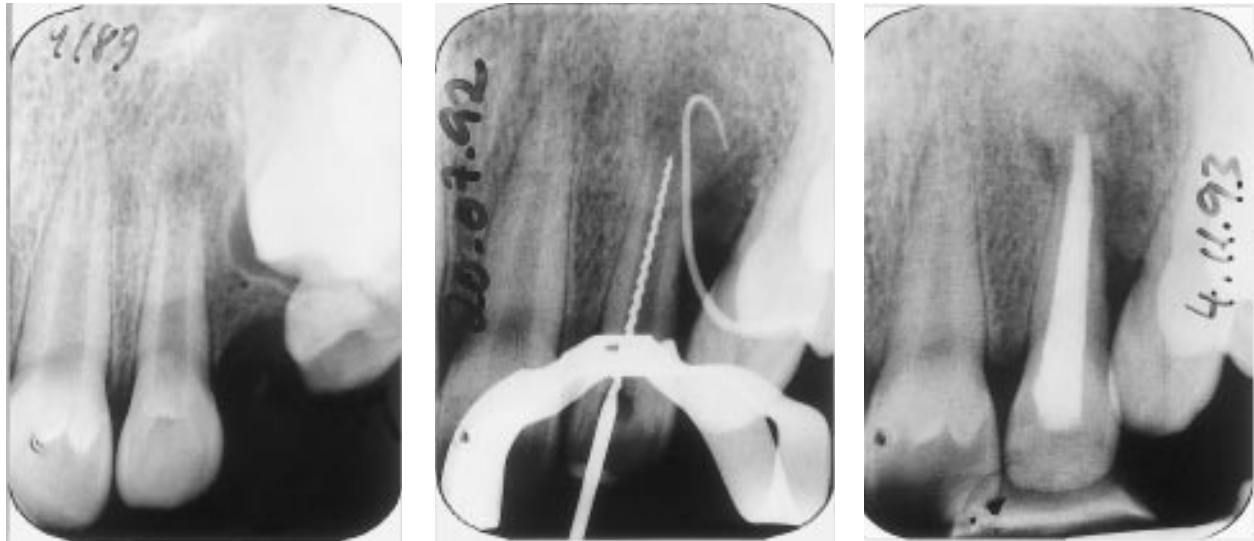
(a) Small coronal invagination in tooth 22. (b) Three years later arrest of root development and pulp necrosis, with apical periodontitis, and sinus tract have appeared. (c) Fifteen months later: following apexification therapy with calcium hydroxide and obturation of the root canal the periapical status has improved.
